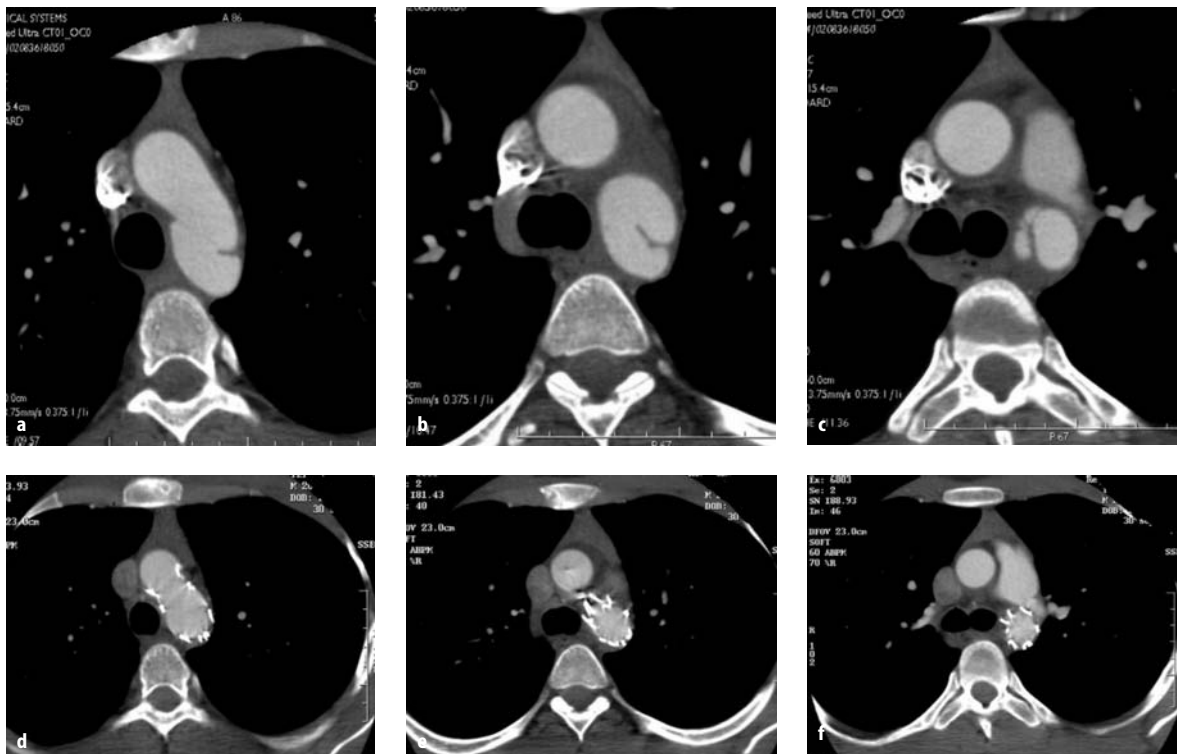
Computed tomography scan imaging showing a–c acute traumatic rupture of the aorta before treatment and d–f 1-year follow-up after covered stent-graft placement. The false aneurysm disappeared
